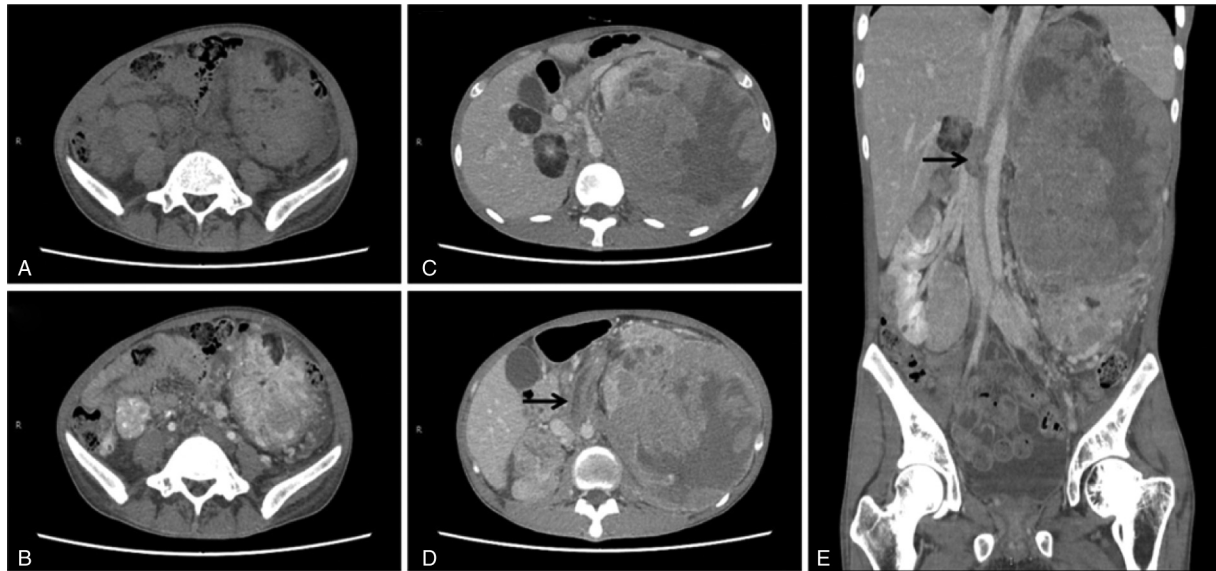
Abdominal contrast-enhanced CT images of EAML in a 24-year-old man. (A) Unenhanced CT scan showed a mass containing some fat content in the left kidney. (B) Contrast-enhanced CT image showed a progressive and heterogeneous enhancement of the tumor. (C) Unenhanced CT scan showed multiple angiomyolipomas in liver. (D) Contrast-enhanced CT image showed tumor thrombosis in left renal vein (black arrow). (E) Contrast-enhanced CT image showed tumor embolus in the post-cava (black arrow). CT: Computed tomography; EAML, epithelioid angiomyolipomas.
